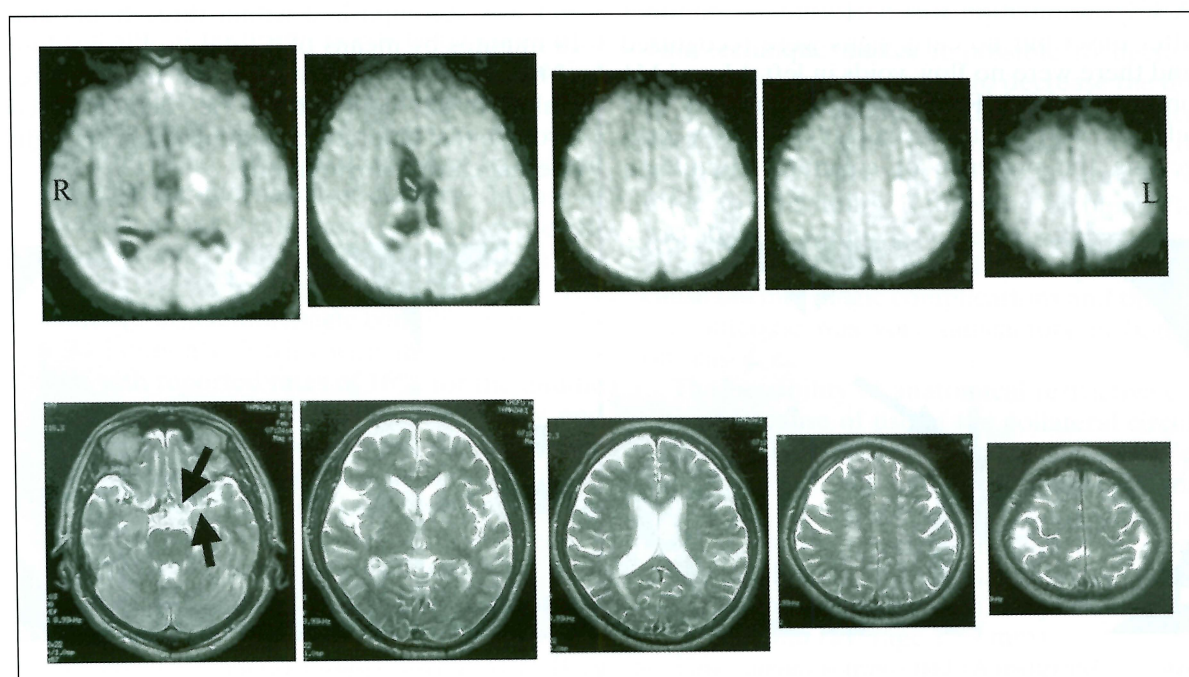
Initial MRI image, axial view, diffusion image (upper) and T2-weighted image showing no vide ischemia and absence flow void of left A1 and M1 proximal (arrow).
